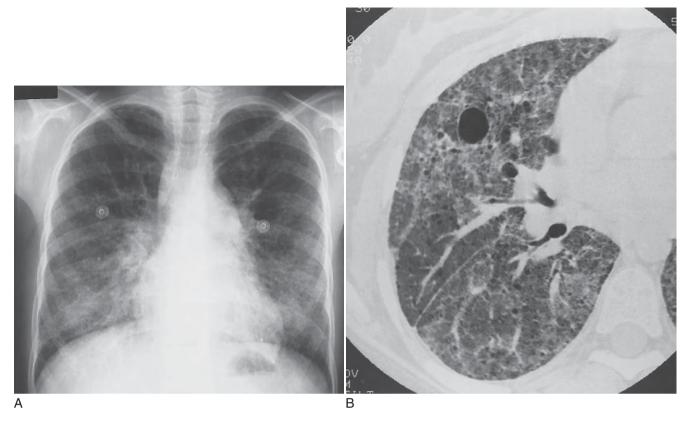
Mixed connective tissue disease with a diffuse reticular nodular infiltrate on chest radiograph (\mathbf{A}). High-resolution CT scan demonstrates diffuse ground-glass opacity with cystic and fibrotic changes (\mathbf{B}). Bronchiectasis is noted peripherally and is better defined than on plain chest radiography.
